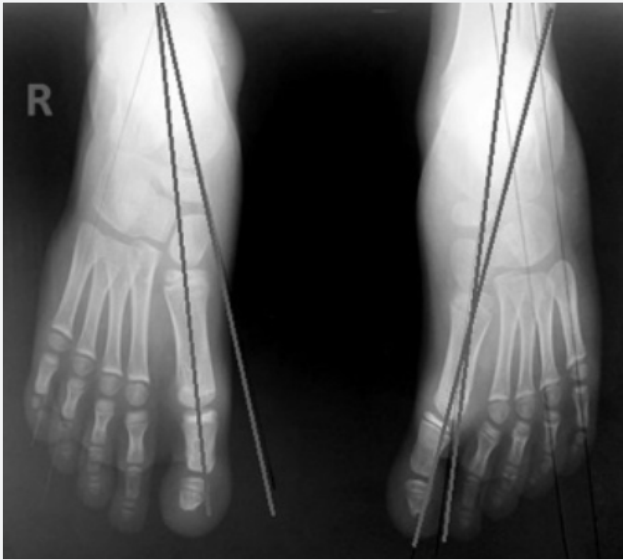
Preoperative standing anteroposterior X-ray showing left metatarsus adductus and normal right foot
